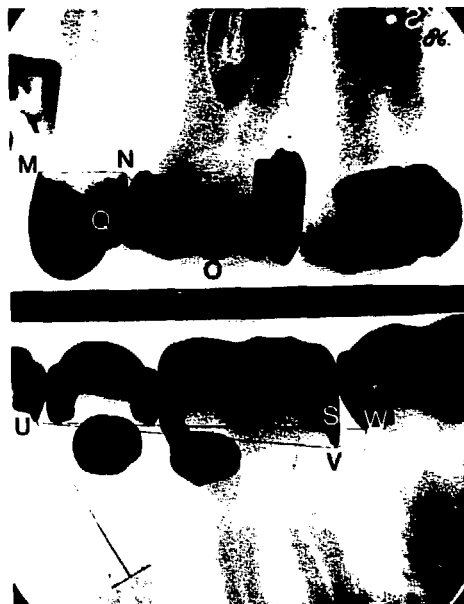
Tenfold magnification of the bite-wing radiograph of a patient on which the sides and the perpendiculars of Δ MNO and Δ UVW were measured to determine the positioning error.
